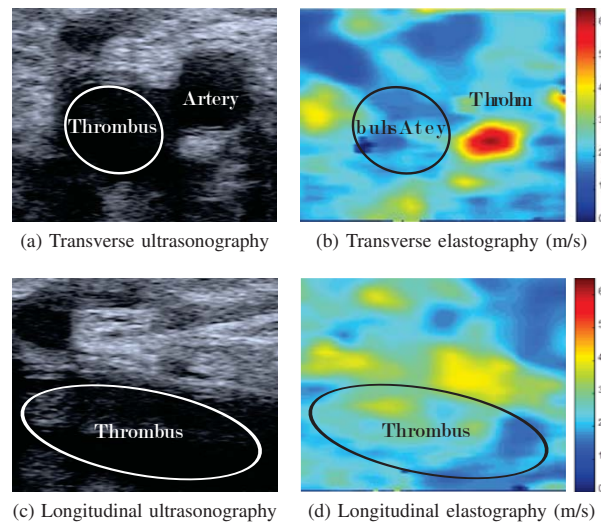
Transverse and longitudinal ultrasonographies and elastographies (speed map) of a thrombus in the femoral vein (images obtained with Toshiba Aplio 500)
